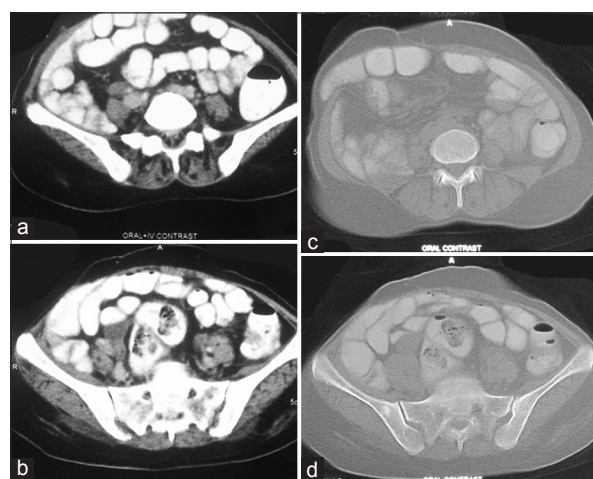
Contrast enhanced computed tomography (CT) of the abdomen, including the visualised bones was within normal limits (a-d)
